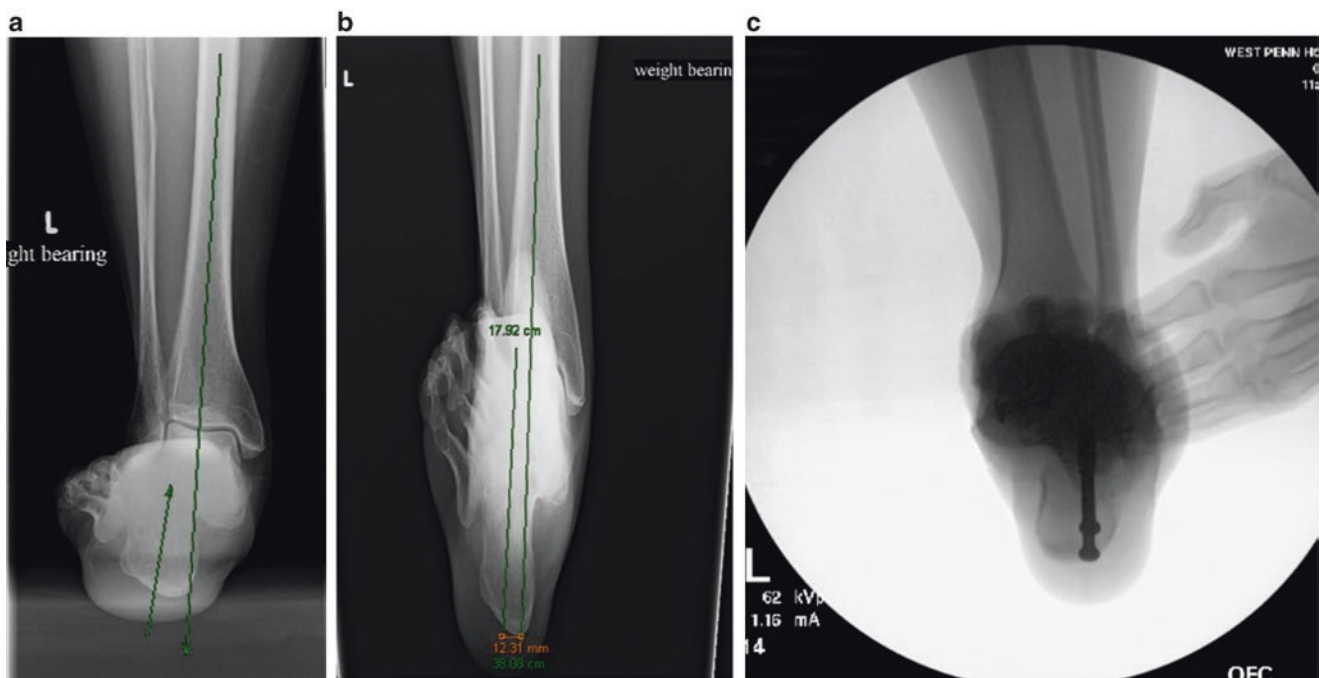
A-B Long-leg axial and hindfoot alignment x-rays. C Intraoperative axial radiograph demonstrating realignment following medial displacement osteotomy of the calcaneus
